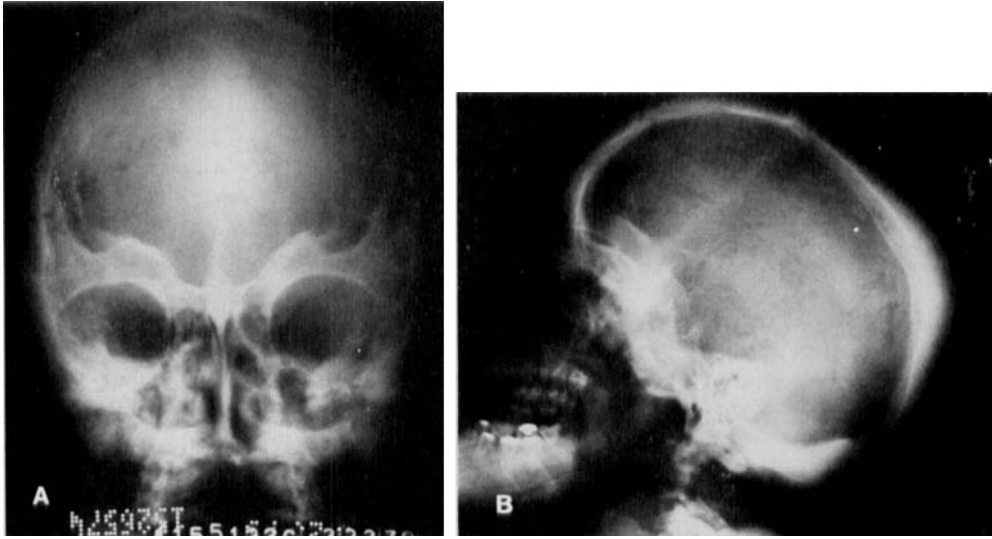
& 1B. (Case 1) Radiographs of skull, AP and lateral. Note the marked thickening of the cranial vault, particularly in the occipital region and in the frontal area. The supraorbital region is particularly thickened.
